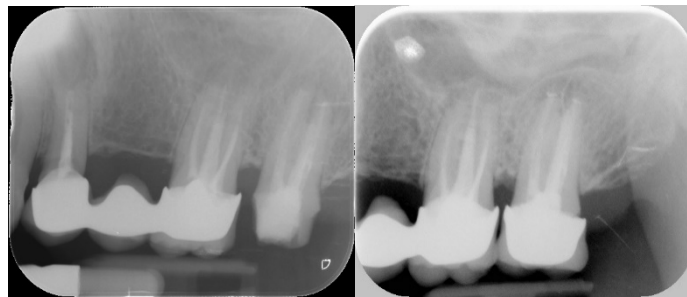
Pre-operative intraoral X-rays.*
